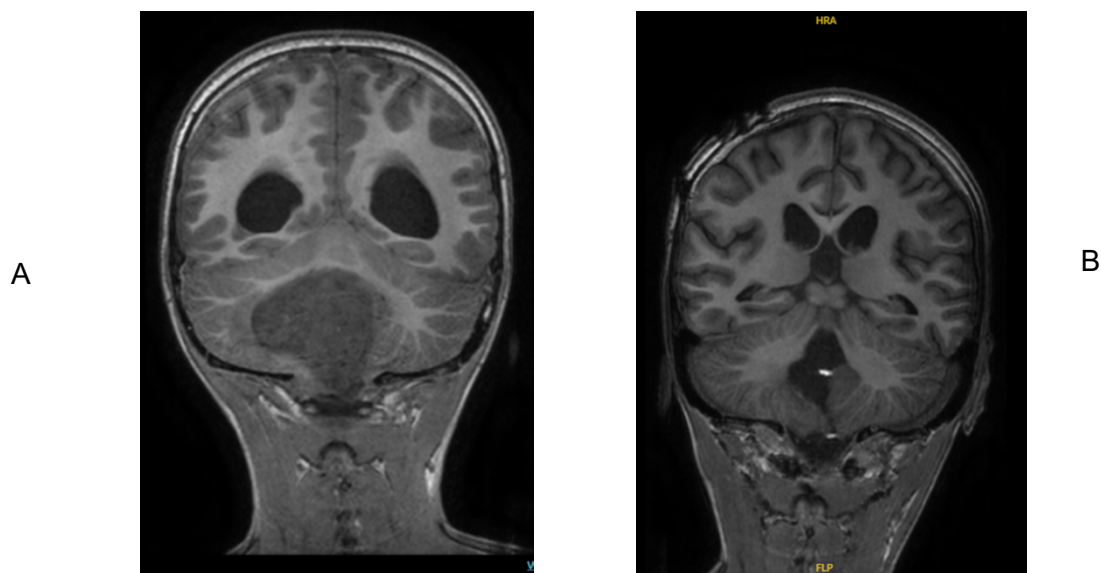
Child 1's pre- and postoperative MRI images of a midline cerebellar mass. (A) Preoperative scan showing the presence of the cerebellar mass in the midline region. (B) Postoperative scan demonstrating near-total removal of the mass
